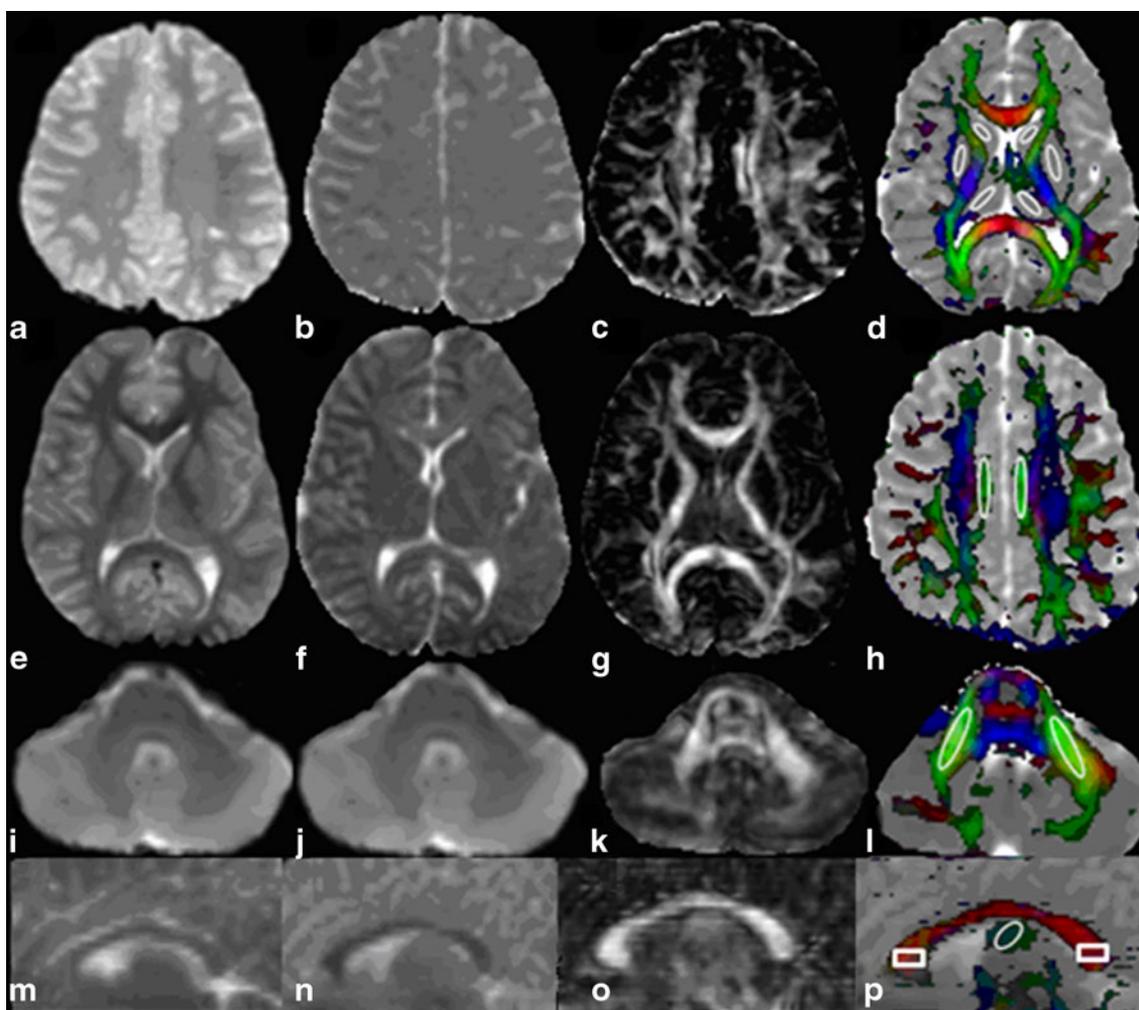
Axial and sagittal images of a 14-year-old patient with spina bifida cystica showing normal appearing cerebral and cerebellar regions of the brain. T2-weighted image, mean diffusivity (MD), fractional anisotropy (FA), and color-coded FA maps at the level of third ventricle (a–d), corona radiata (e–h), pons (i–l), and massa intermedia (m–p) showing region-of-interest placed on color-coded
